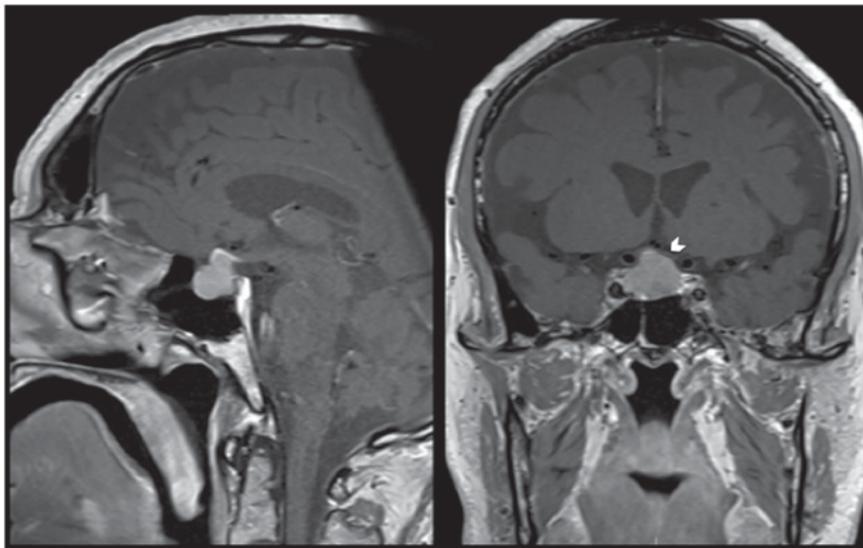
Sagittal (left panel) and coronal (right panel) views of a gadolinium enhanced T1-weighted cerebral magnetic resonance imaging revealing a sellar lesion with suprasellar extension, and intense homogeneous contrast enhancement. The pituitary stalk is not visible and the compression of the optic chiasm is evident (the left optic nerve is flattened just above the roof of the tumor and it is marked with an arrow head).
